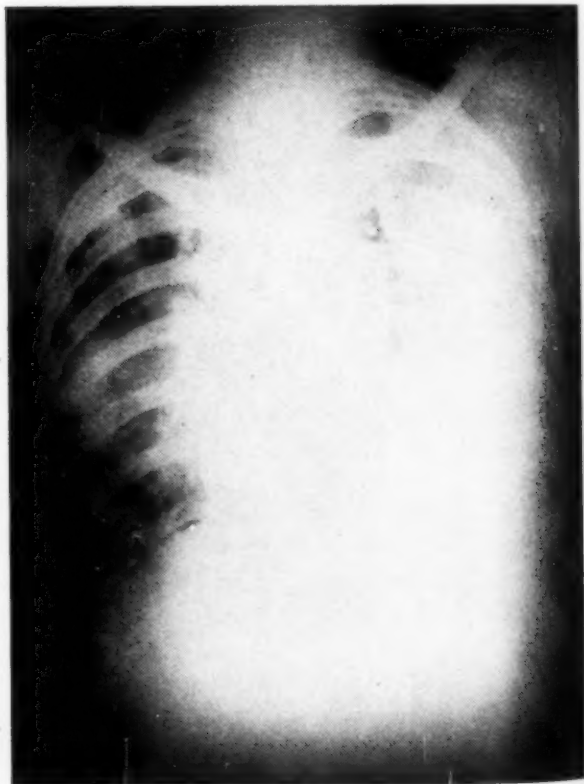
X-ray examination revealed a moderate infiltration throughout the entire right lung. An area of increased density was present along the periphery of the left lung from the first interspace to the dome of the diaphragm.
